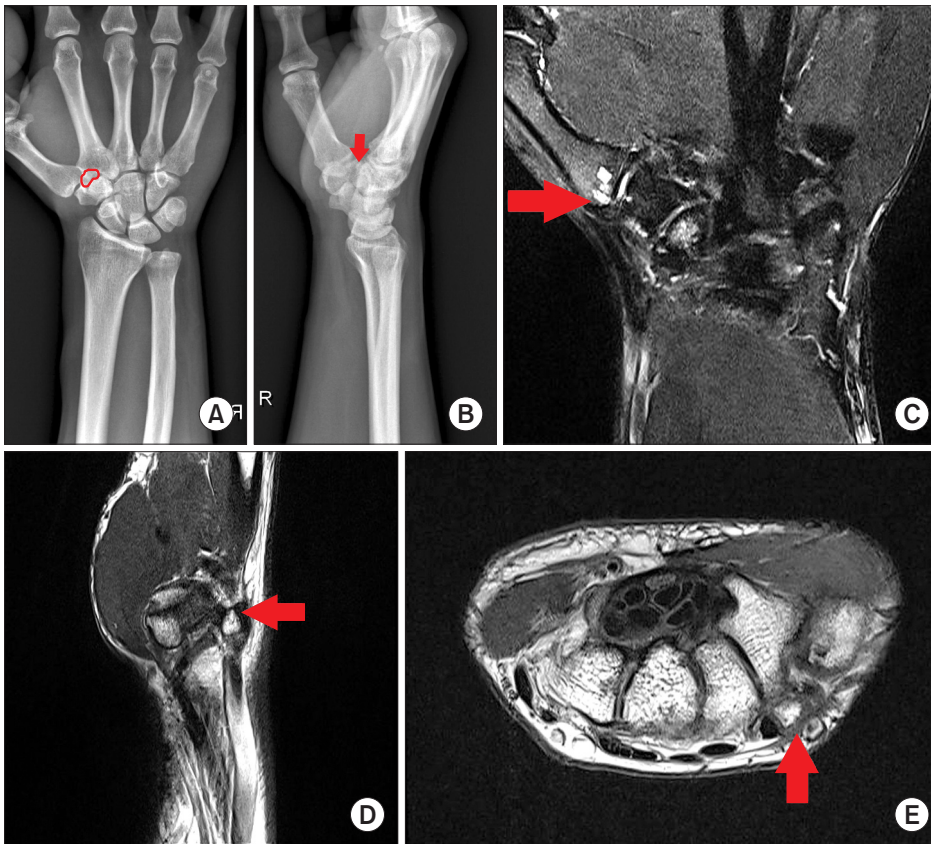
On plain radiographs, an osteophyte (circle&arrow) is suspected around the dorsum of the right first CMC joint. (A, B) on the right wrist magnetic resonance imaging, osteoarthritic changes and subchondral cysts of the first metacarpal base (arrow) are observed around the first CMC joint (C) and the osteophyte (arrow) in the dorsum of the first CMC joint (D, E). CMC: carpometacarpal.
